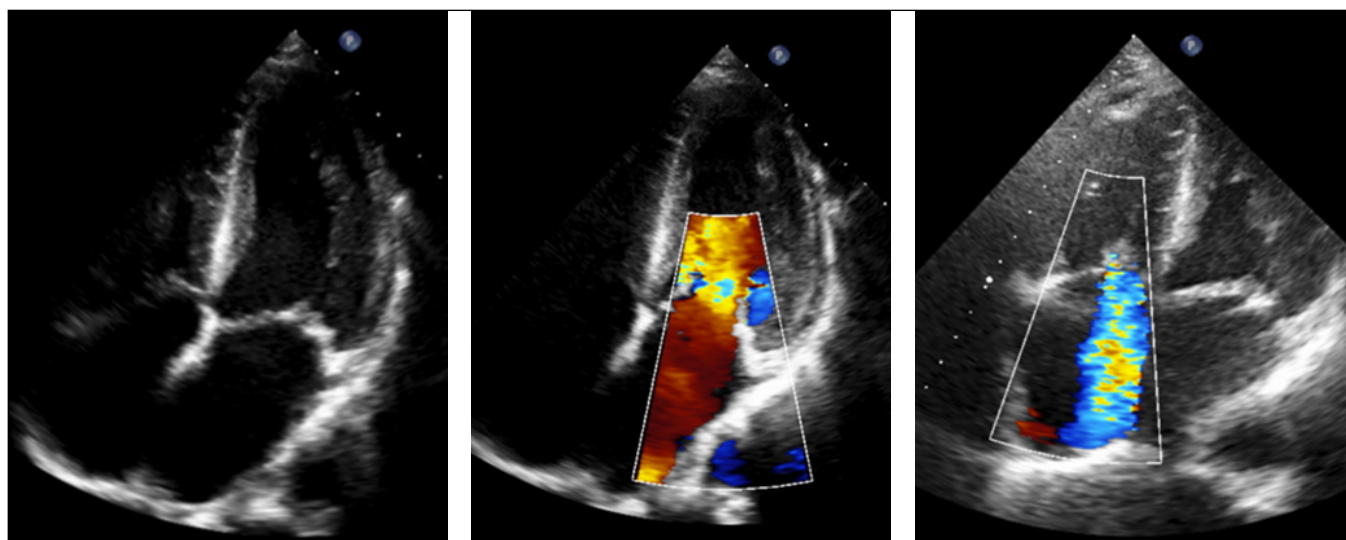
Transthoracic echocardiography, apical four-chamber view. Concentric LV hypertrophy. Right atrial enlargement. Pronounced dilation of the LA with normal LV dimensions. Pronounced aortic valve regurgitation (incomplete leaflet coaptation). Relative mitral valve insufficiency, grade I-II. Pronounced tricuspid regurgitation against the background of dilation of the fibrous ring. Signs of pronounced left ventricular hypertrophy. Dilation of the ascending aorta. Thickening of the aortic walls, likely of specific etiology.
